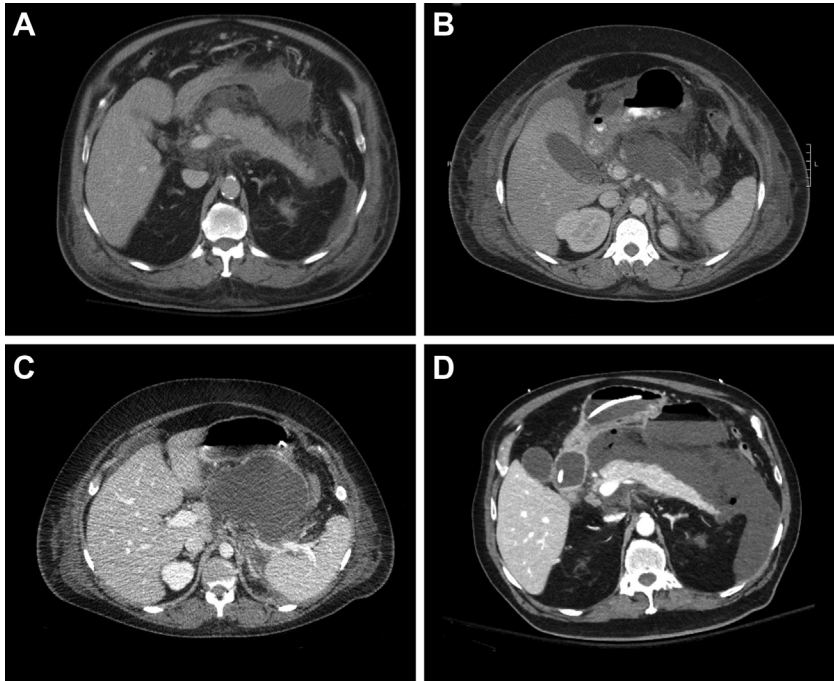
Stages of necrotizing pancreatitis. Computed tomography (CT) imaging depicting the stages of necrotizing pancreatitis. (A) Acute pancreatitis with *peripancreatic fluid collection*; (B) necrotizing pancreatitis with an *acute necrotic collection* and a viable pancreatic tail; (C) necrotizing pancreatitis with *walled-off necrosis* abutting the posterior wall of the stomach; (D) necrotizing pancreatitis with gas bubbles throughout the collection, indicative of *infected necrosis*.
